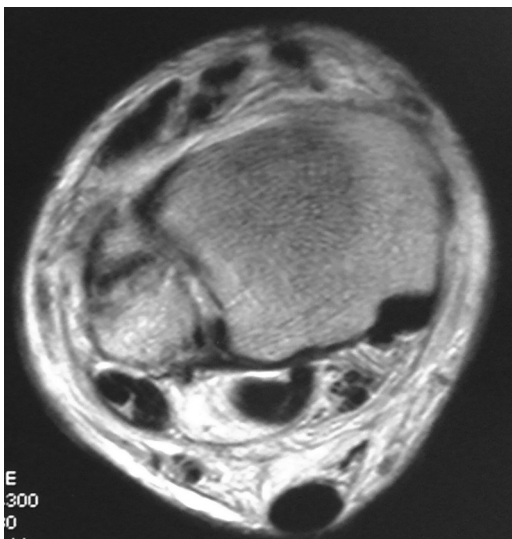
Magnetic resonance imaging scan of the right ankle confirming rupture of the syndesmosis ligament.
